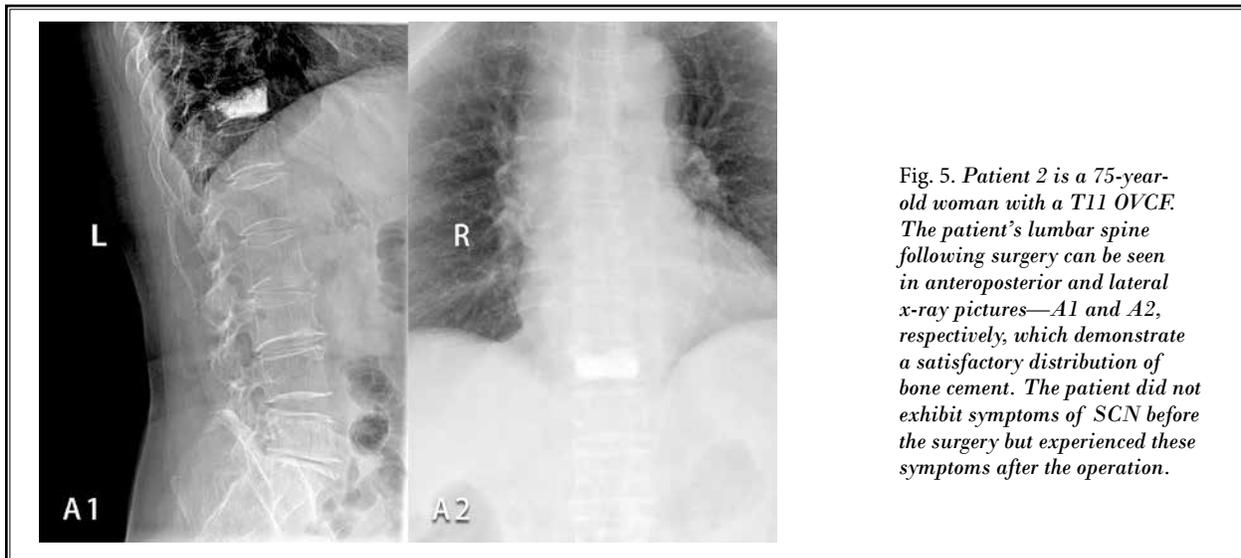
Patient 2 is a 75-year-old woman with a T11 OVCF. The patient's lumbar spine following surgery can be seen in anteroposterior and lateral x-ray pictures—A1 and A2, respectively, which demonstrate a satisfactory distribution of bone cement. The patient did not exhibit symptoms of SCN before the surgery but experienced these symptoms after the operation.
